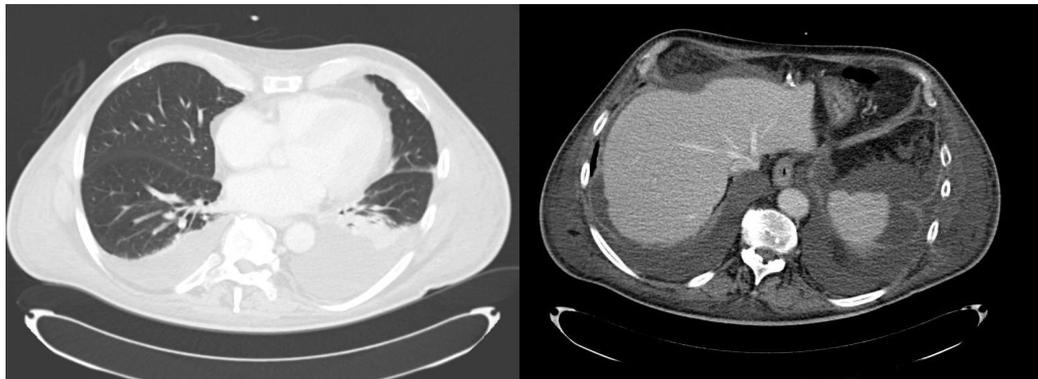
CT scan showing bilateral pleural effusion.
